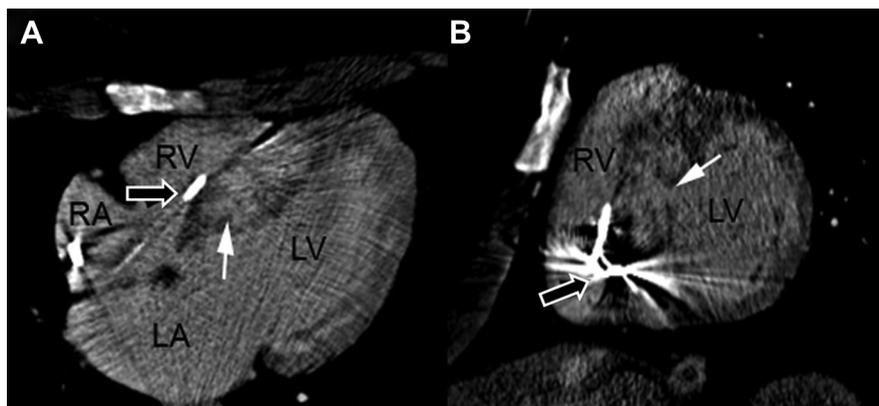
Delayed cardiac CT scan of a 26-year-old female patient with 55.1 g of myocardial fibrosis and appropriate shock by implantable cardioverter defibrillator shown in 4-chamber (A) and short-axis (B) views. Extensive myocardial fibrosis is present in the interventricular septum (white arrows). An implantable cardioverter defibrillator lead artifact is present (black arrows). LA, left atrium, LV, left ventricle, RA, right atrium, RV, right ventricle.
